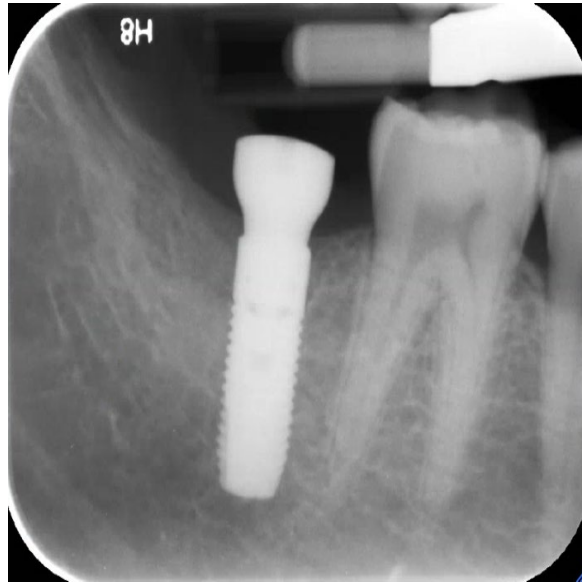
An intraoral periapical radiograph of the mandibular right posterior region showing implant #47 with a healing abutment in place
